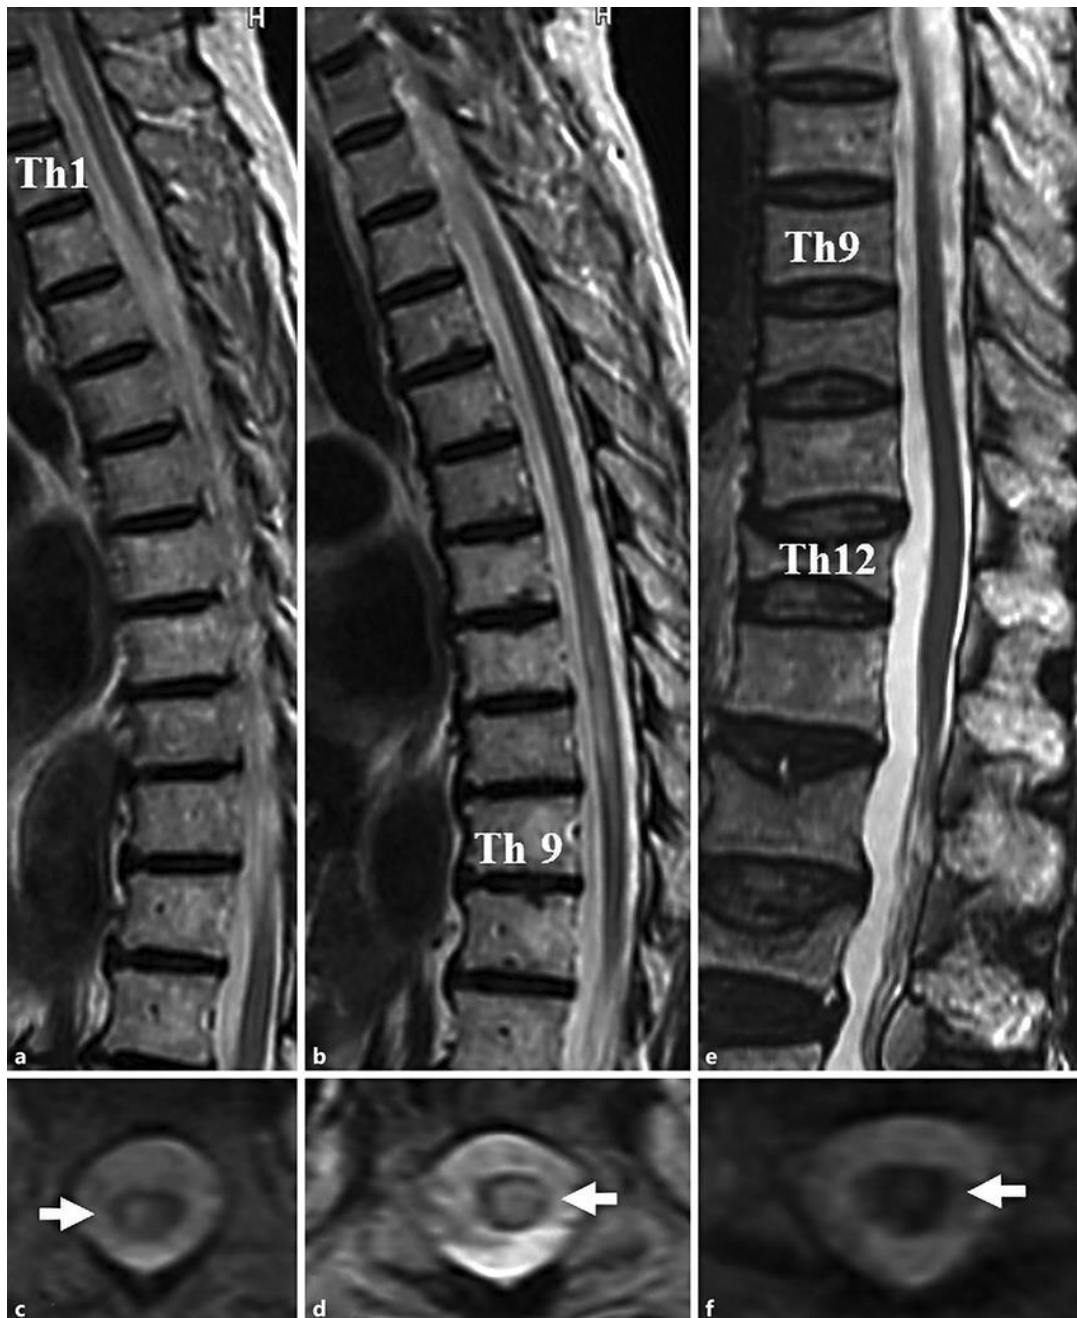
Sagittal thoracic spine magnetic resonance imaging (MRI) on admission in case 1 showing high-intensity lesions extending from Th1 to Th2 and from Th7 to Th9 on T2-weighted image (T2WI) (a, b). Axial thoracic spine MRI showing high signals in the central part of the cord at the Th2 and Th8 levels on T2WI (c, d, arrows, respectively). Sagittal thoracic spine MRI on admission in case 2 showing high signals extending from Th9 to Th12 on T2WI (e). Axial thoracic spine MRI showing high signals in the central part of the cord at the Th9 level on T2WI (f, arrow).
